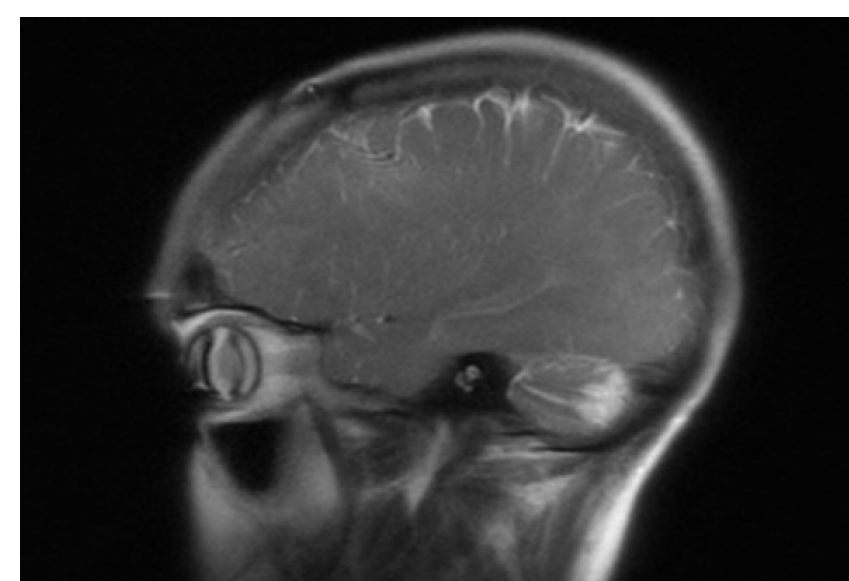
Sagittal T2 MRI Brain, demonstrating hyperintensity of the cerebellum
